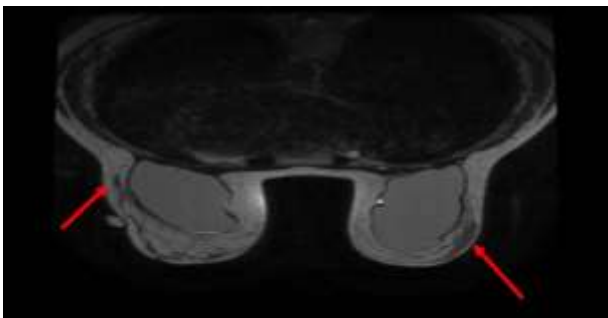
The MRI of the case presentation: showing the malignant lesion on the left (MRI 6), and the area with increased enhancement on the contralateral breast (MRI 3).
